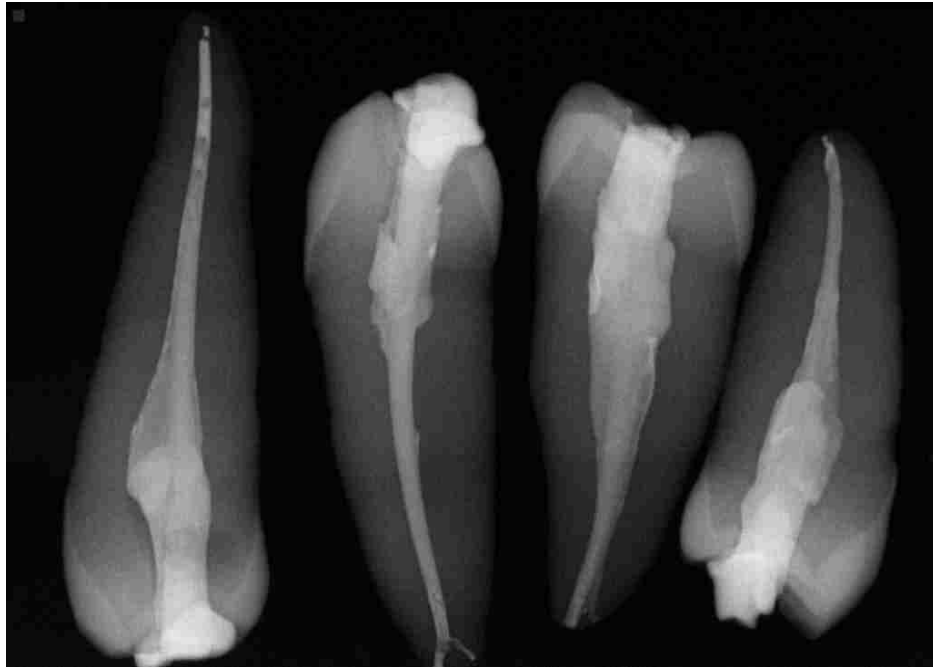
Radiograph of teeth obturated with warm vertical condensation of gutta- percha.
